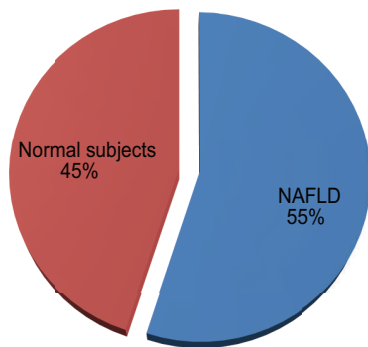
Distribution of patients according to liver ultrasound findings (n=100)*
